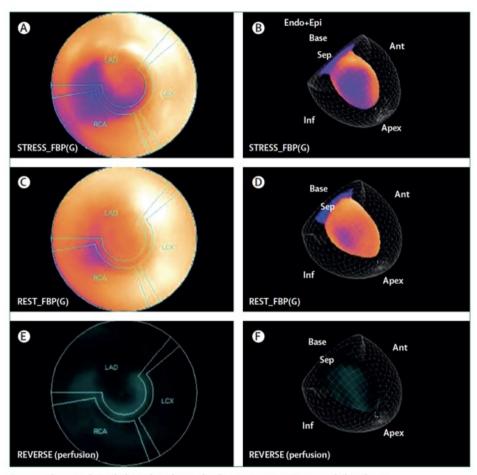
Pharmacological (dipyridamole) single-photon emission CT myocardial perfusion
